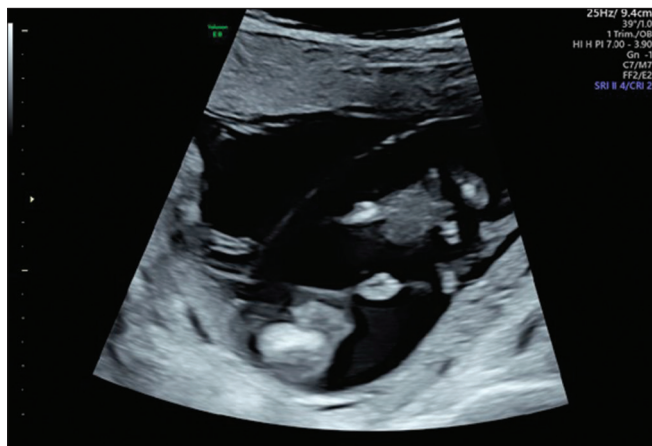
First-trimester ultrasound: chorionicity determination at 12 weeks of gestation, where a T-sign and a single placental mass may be observed, compatible with monochorionic diamniotic twin pregnancy
